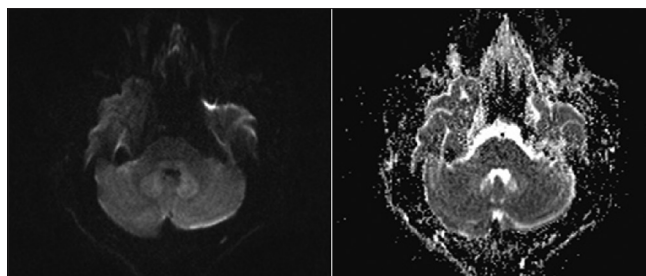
Bilateral cerebellar dentate nuclei showing restricted diffusion as iso to slightly hyperintense signal noted on the DWI, with isointense signal in ADC
